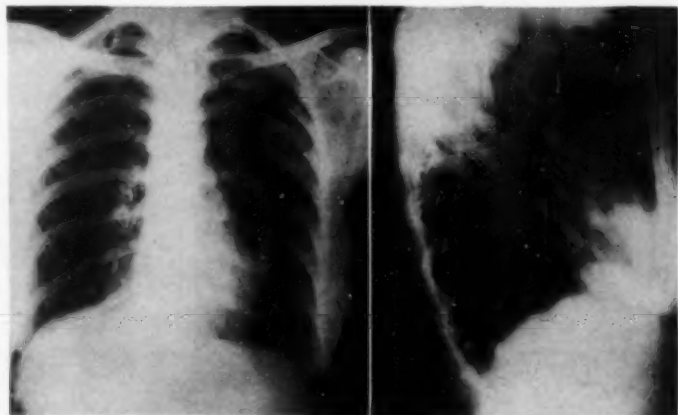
Posterior-anterior and lateral radiographs showing a density in the lingula of the left upper lobe and one in the right middle lobe.
